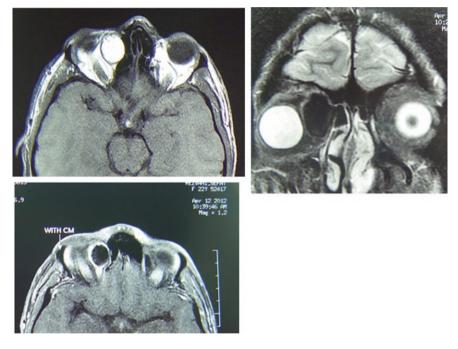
Shows MRI findings of orbital dermoid cyst. a Shows a hyper-intense mass in T1W image that is hypo-intense in T2W (b) and after contrast administration not only does not enhance but seems to be smaller (c)
